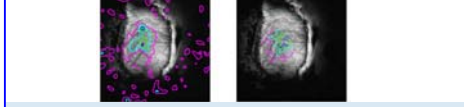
Contours of 0.8, 0.6 and 0.2*max of BOLD (left) and Hb (right) superimposed on MRI surface reconstruction.
